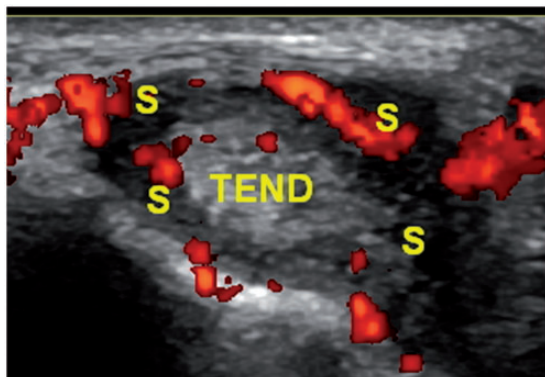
Cross-sectional image of tendon (Tend) and sheath showing Doppler flow within tendon and thickened sheath (S).
